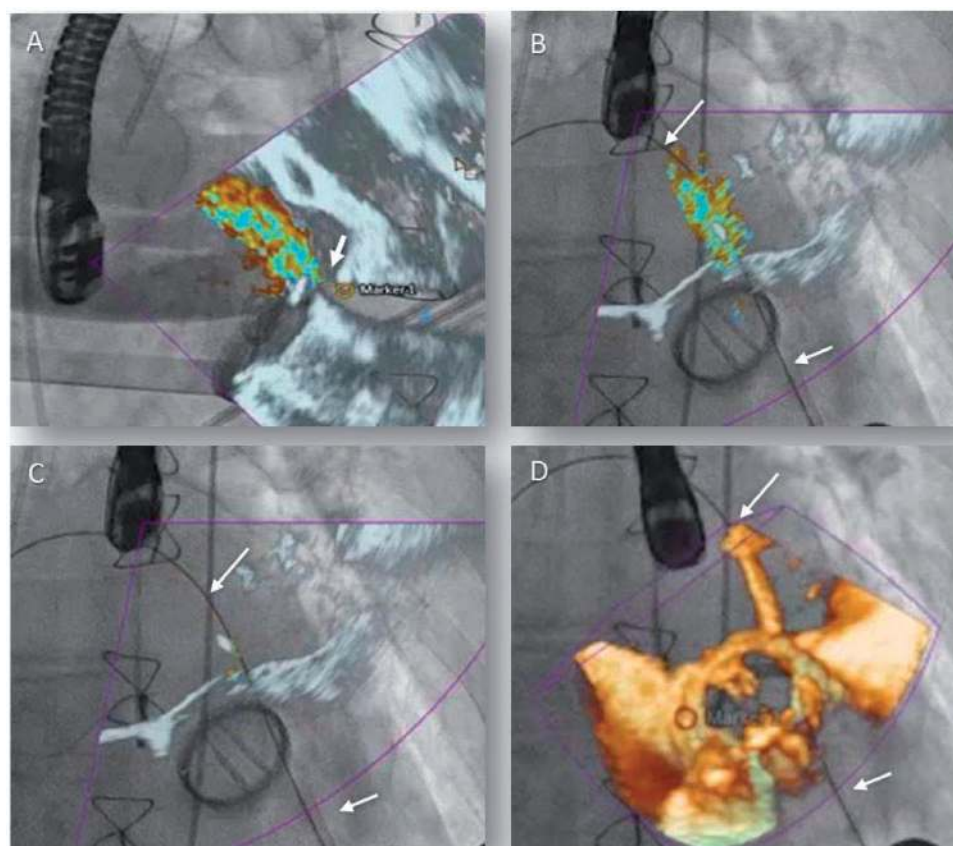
(A) 2D colour Doppler fused image showing the regurgitant jet originating from the paravalvular leak (arrow). (B) Colour Doppler (as well as fiducial markers) may facilitate the interventionalist in crossing the leak. The arrows point the guide wire across the leak. (C and D) Same step in 2D and 3D image.
